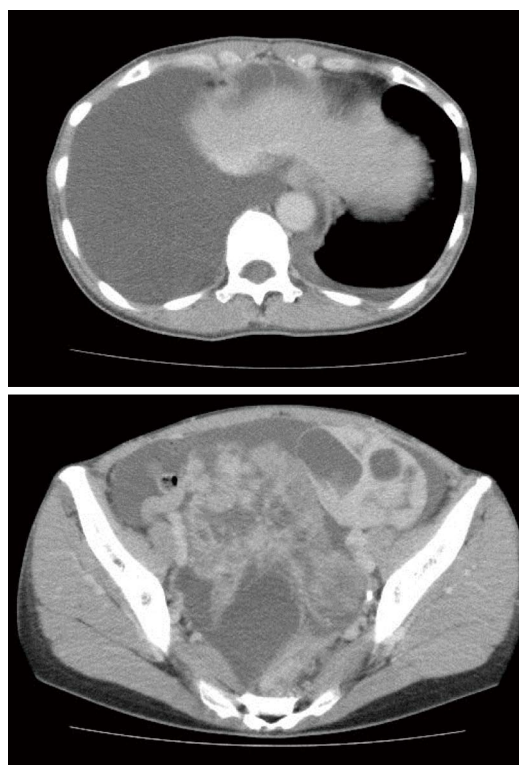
Whole body computed tomography-scan demonstrating bilateral enlarged ovaries, ascites and bilateral pleural effusion.
